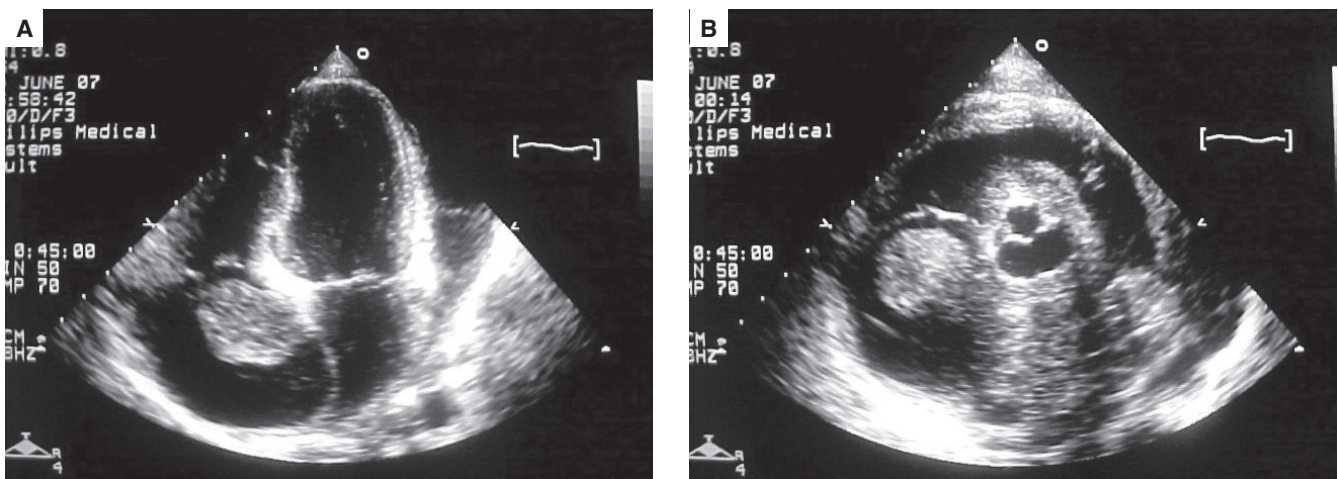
Echocardiography. A. Four-chamber view showing dilation of the right atrium, which contains a large mass attached to the interatrial septum, partially occluding the flow through the tricuspid valve. Notice the presence of moderate pericardial effusion. B. The short-axis view, at the level of the aortic valve, shows thickening of the aortic cusps and the tissue surrounding the valve. The right atrial mass is also seen attached to a thickened interatrial septum.
